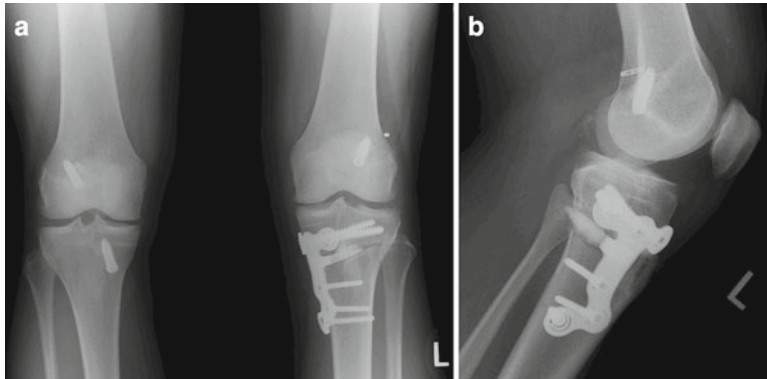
Case 1: Postoperative radiographs after HTO and ACL revision with soft tissue allograft (proximal extracortical fixation and tibial fixation with staples). (a) AP and (b) lateral views. Note in (b) the posterior plate positioning, in order to decrease the tibial slope
